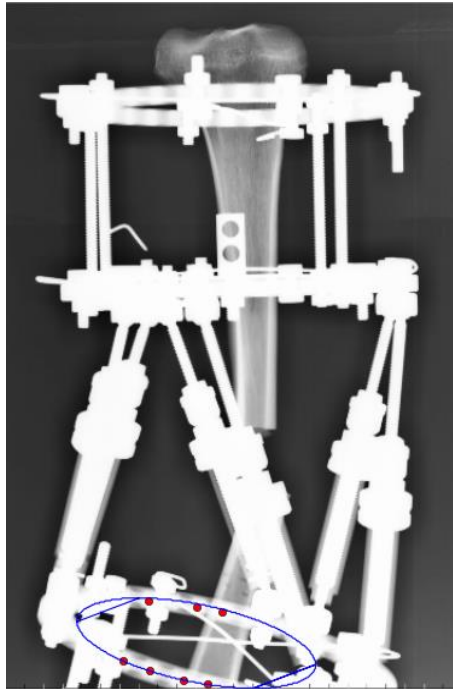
Semi major axis constrained direct ellipse fitting applied to the X-Ray image.
